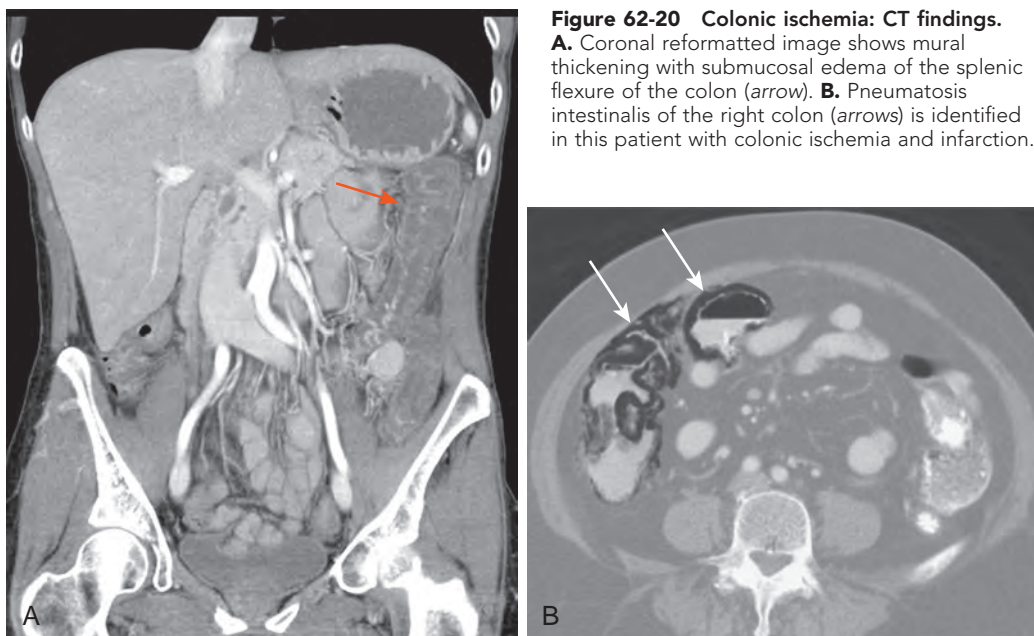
Colonic ischemia: CT findings.
